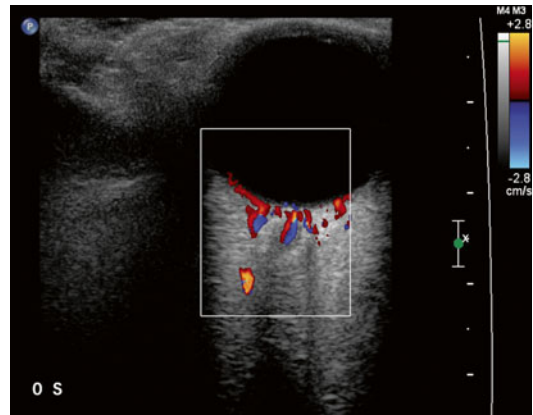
Color Doppler image of the eye and orbit in a healthy person. The normal blood circulation is well seen in the central retinal artery and vein and in the short ciliary arteries and in the choroid-retina
